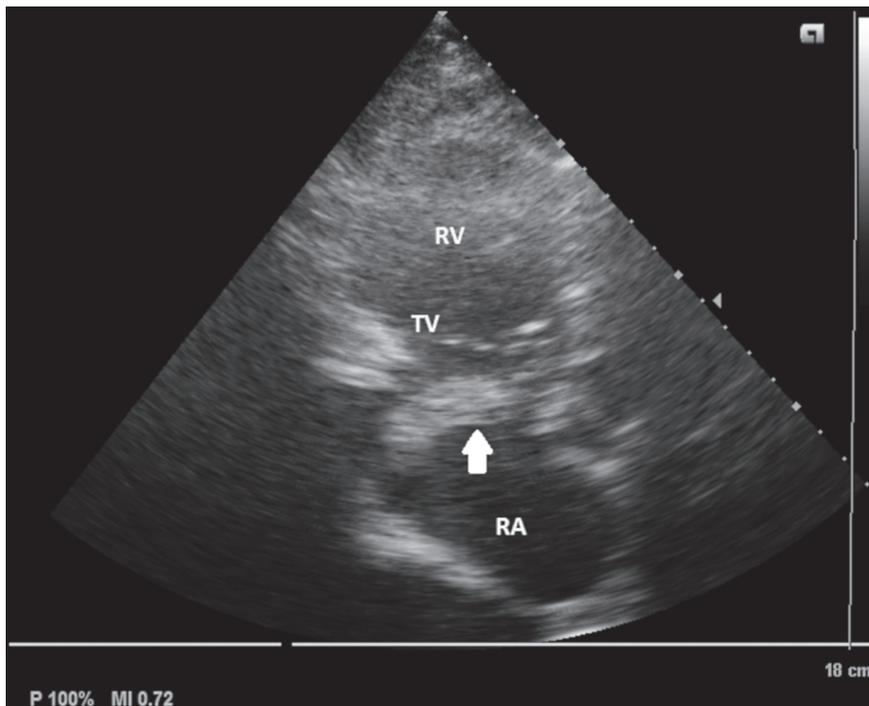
Bedside echocardiography revealed a large, elongated, free-floating thrombus (white arrow) in the right atrium (RA – right atrium; TV – tricuspid valve; RV – right ventricle).
